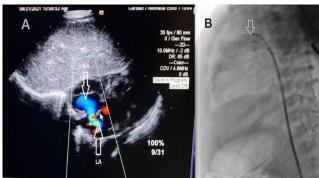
Post balloon atrial septostomy echocardiography, subcostal coronal view showing adequate septostomy with good flow, shunting right to left (arrows indicating RA and LA) with cursor pointing at the inter atrial septum. Figure-2B: Aortogram in left anterior oblique (LAO) 90° showing the PDA stent (arrow) in place.
